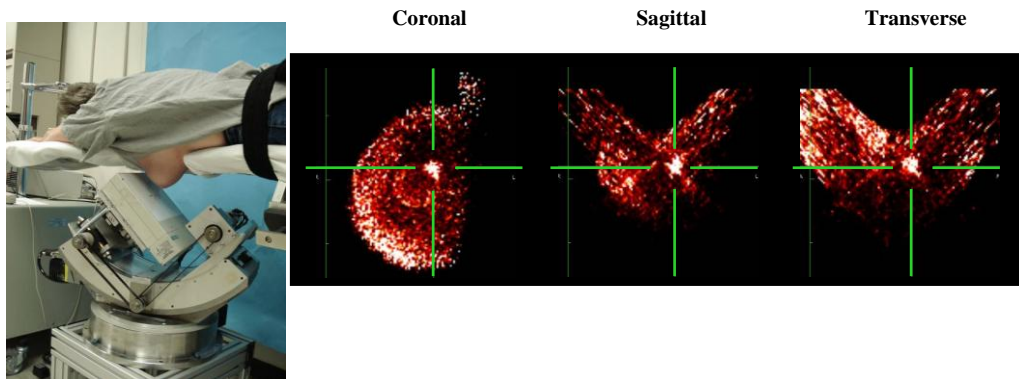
(FAR LEFT) Photograph of the subject on the preprototype bed, suspended over the dedicated breast SPECT system. (RIGHT IMAGES) Reconstructed images of the breast are in coronal, sagittal, and transverse views. Confirmed lesion on the subject's anterior chest wall is indicated at the intersection of the green hash marks
